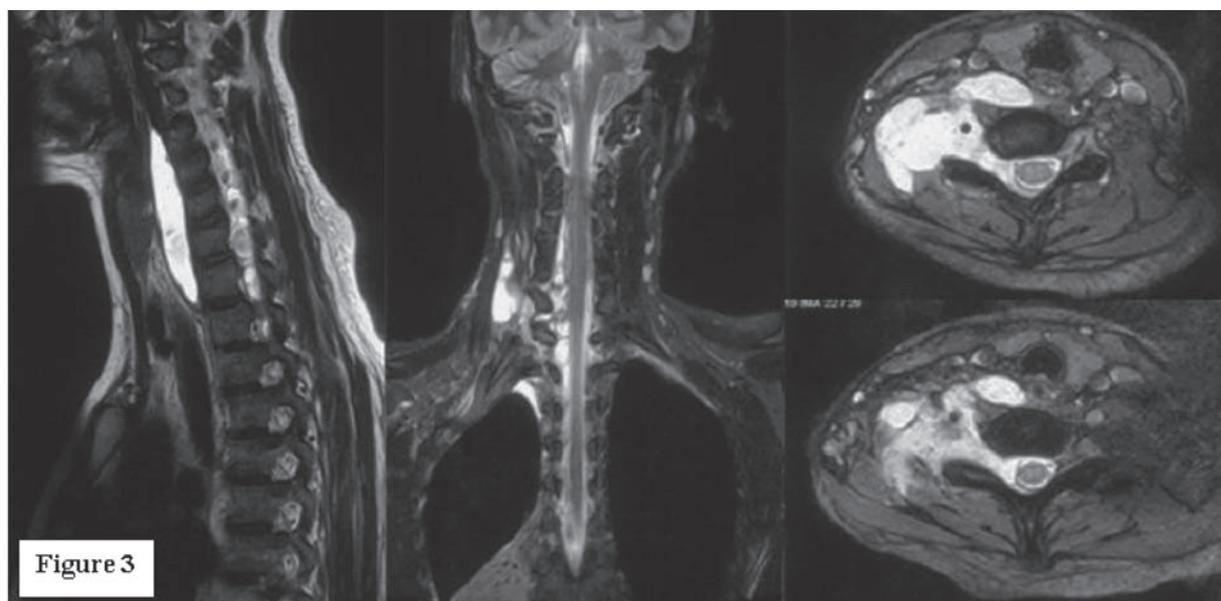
MRI scan showed a haematoma collection extending from C6 to T1 levels which compressed the spinal cord and resulting the spinal cord to be shifted to the left side. There was also presence of prevertebral haematoma noted.
